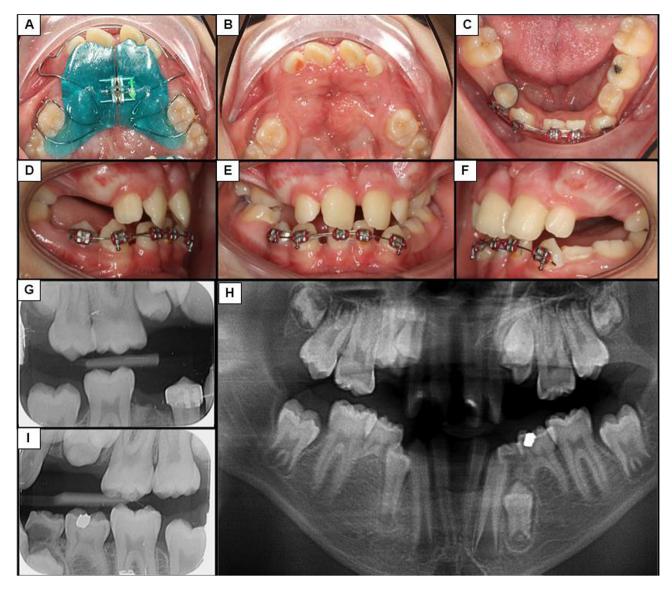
Intraoral photographs, panoramic and intraoral radiographs of case F1-III:2. (A) Orthodontic removable appliance for expansion, (B) the upper jaw and palatal cleft, (C) the lower jaw, (D) view from the right, (E) front and (F) left side, H) panoramic radiograph shows mixed dentition with radiculomegaly affecting teeth 11, 21, 33, 32, 42, 43, (G) right bitewing radiograph, (I) left bitewing radiograph
